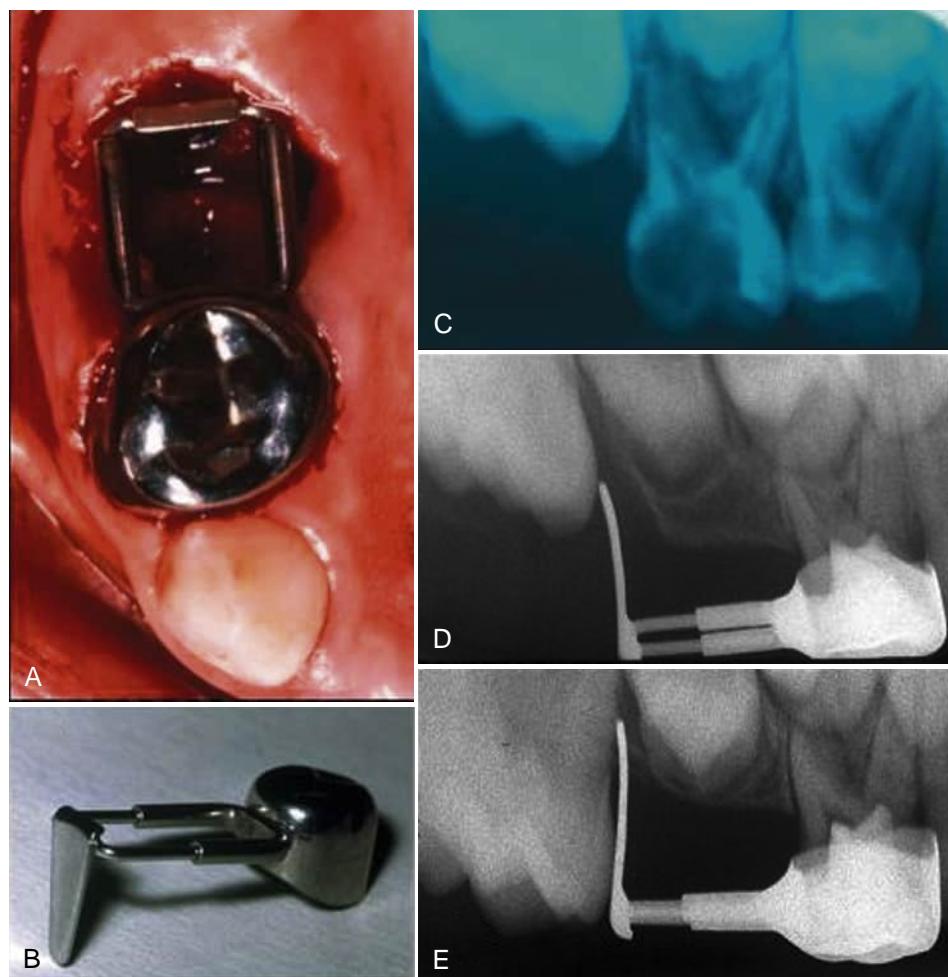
(A) The second primary molar is nonrestorable and must be extracted. A crown with a distal shoe extension to help guide the first permanent molar has been placed. (B) Picture of a prefabricated crown with Gerber-type distal shoe extension as used in the case. (C), (D), and (E) Progress can be seen on radiographs in guiding the eruption of the permanent molar over 12 months.
